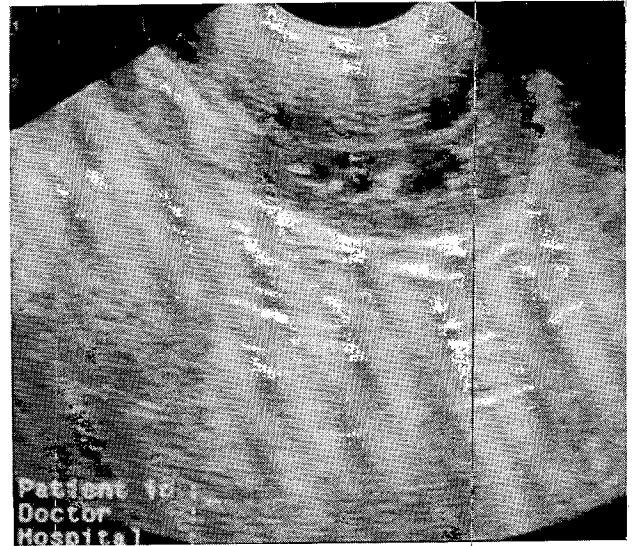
Ultrasonographic view of a reflective structure with acoustic shadowing in a kidney.
